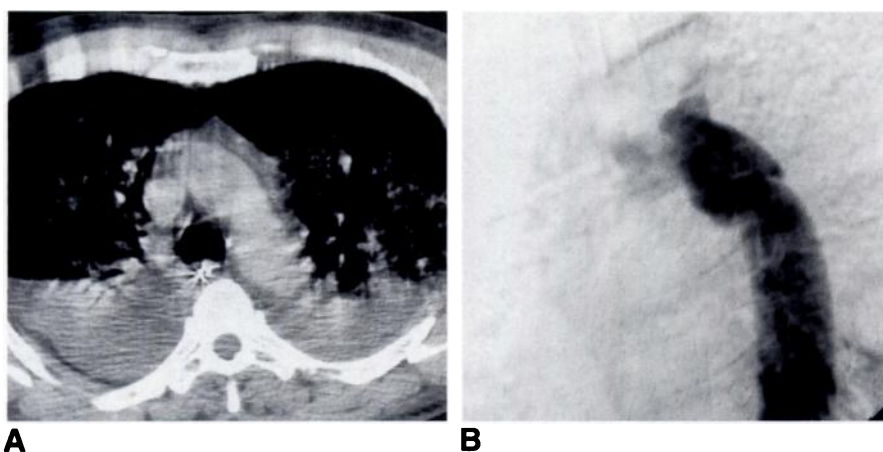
Modest-sized mediastinal hematoma shown by CT in a 48-year-old man who was injured in a motor vehicle accident.
